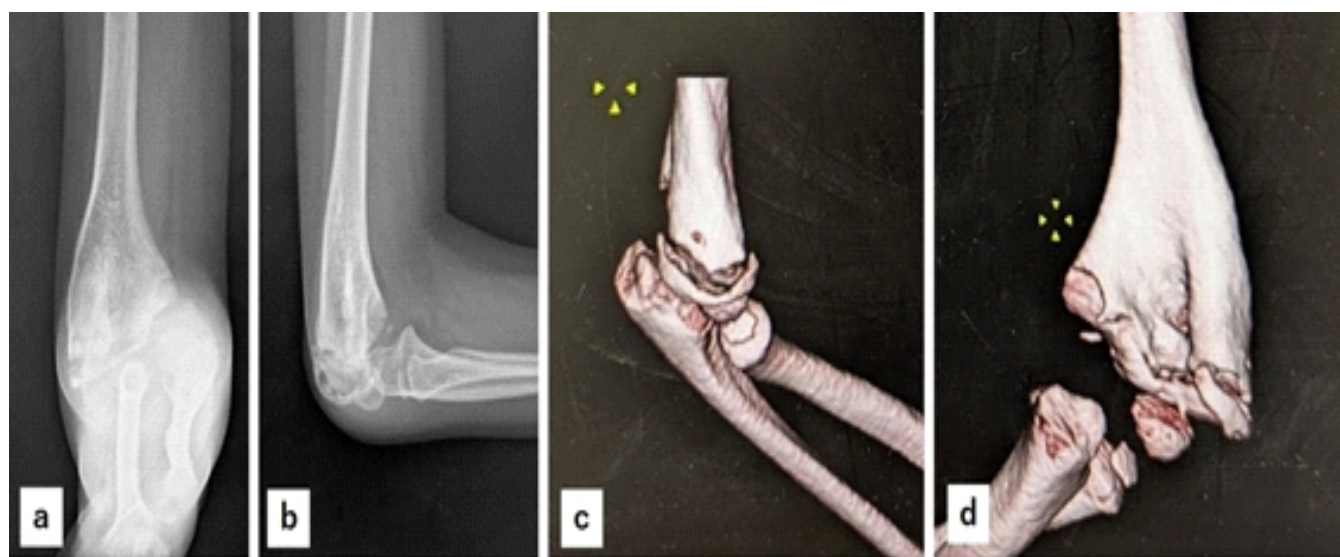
X-ray and 3D computed tomography (CT) images at the time of initial visit to our hospital. X-ray (a): Anteroposterior view, (b): Lateral view, and 3D CT images (c): Lateral view, (d): Posterior view show marked varus deformity of the humerus and non-union of the lateral condyle fracture.
